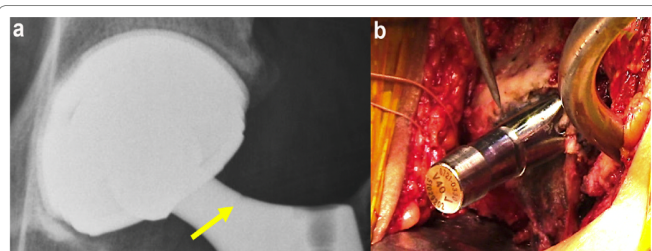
Case 2: Pre-revision anteroposterior radiograph showing neck stem notching (a). Notching on the superior aspect of the femoral neck seen intra-operatively (b).
